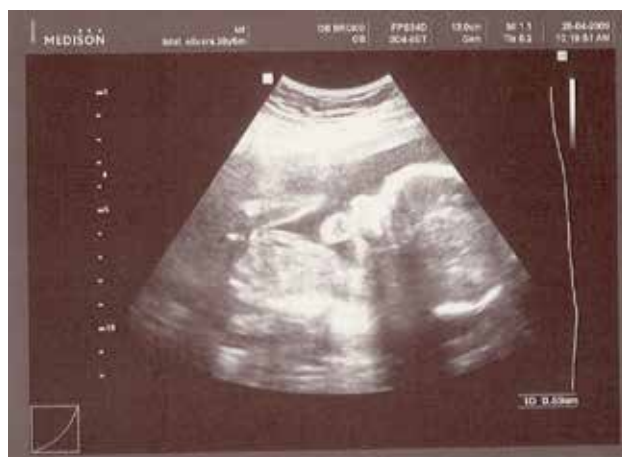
Ultrasound examination: asymmetric IUGR of the fetus and micrognathia
